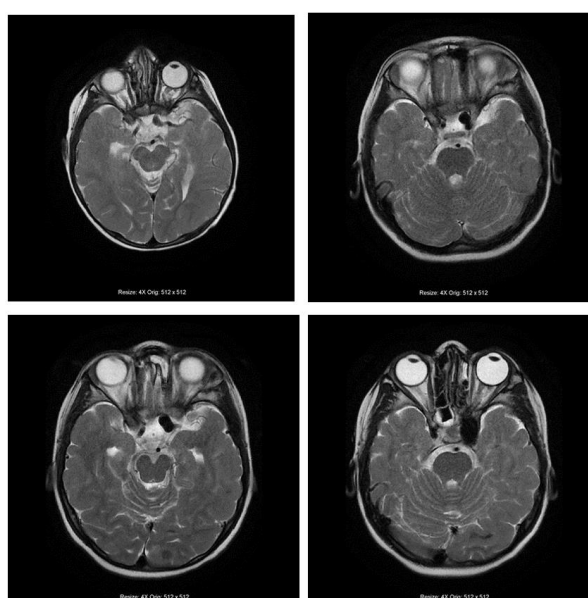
Progression of aneurysmatic enlargement at the level of the cavernous segment of the left internal carotid artery in axial images in T2-weighted sequence in the cerebral MR examination of the patient taken 1 year apart.
